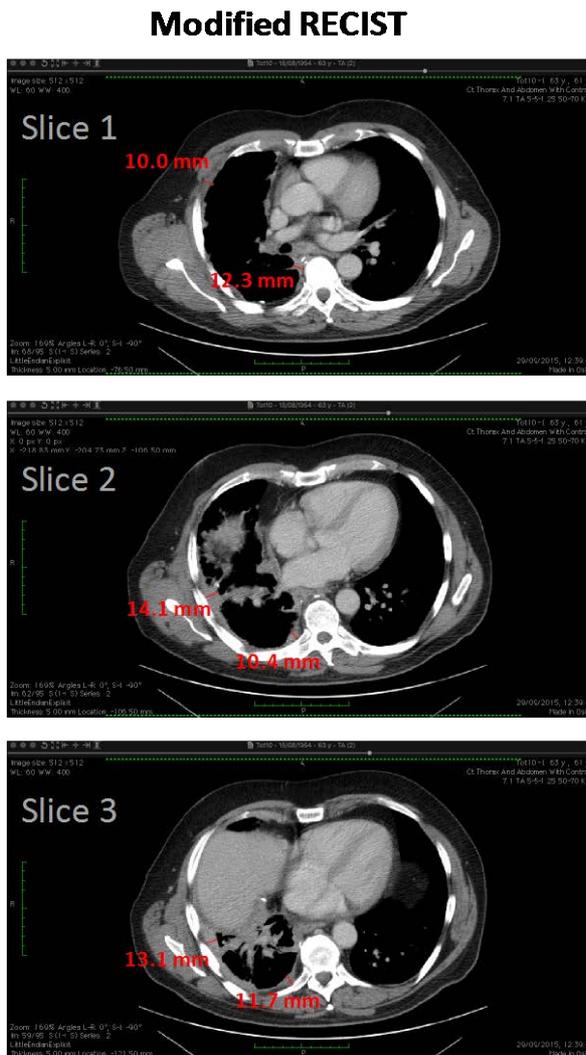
Tumour measured based on modified RECIST for a 61-year-old male patient at a baseline CT scan. The tumour was measured in two positions on three transverse images of the CT scan which are at least 10mm apart. The sum of the six measurements for this patient, 71.6 mm, is the total measurement for baseline CT scan.
